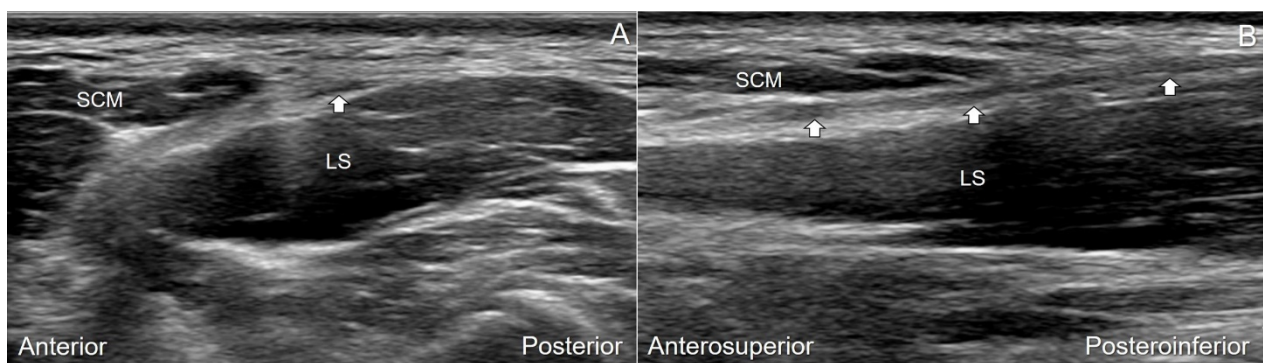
Ultrasonography of the right spinal accessory nerve (white arrow) in its short-axis (A) and long axis (B). SCM, sternocleidomastoid muscle; LS, levator scapula muscle.
